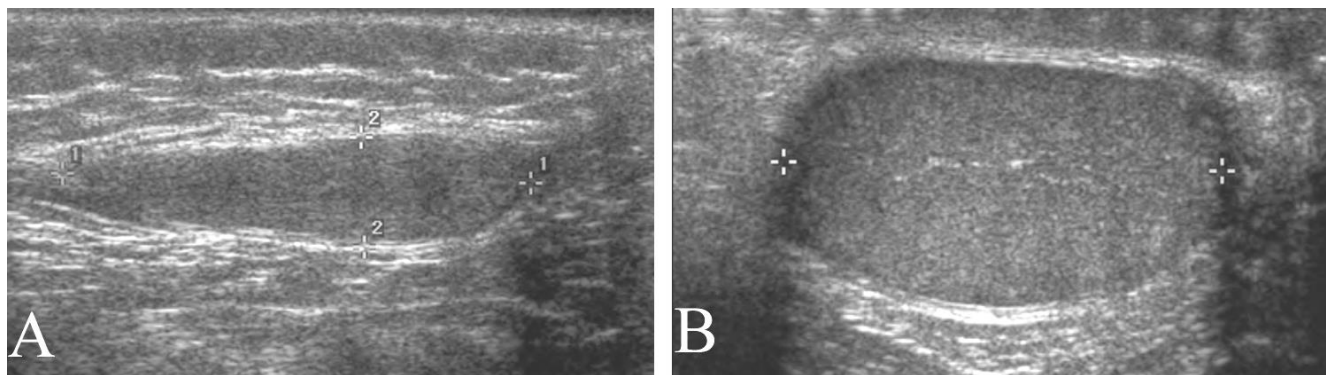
Undescended testicle in a 10 year old with a single testicle palpated in the scrotum. A. Ultrasound shows that the undescended testicle is in the inguinal canal and shows an abnormal, elongated appearance. B. The contralateral, normal, descended intrascrotal testicle.
